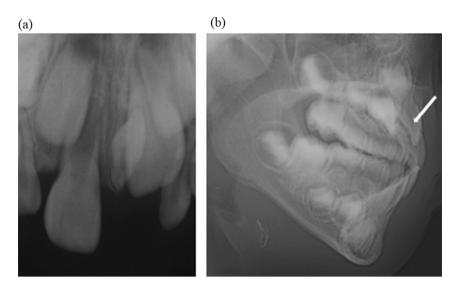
Initial radiographs, at 6 years of age. (a) Periapical radiograph: the root formation of the supernumerary tooth was near complete. (b) Lateral cephalogram: a supernumerary tooth (arrow) can be seen on the palatal side of the maxillary central incisor.
